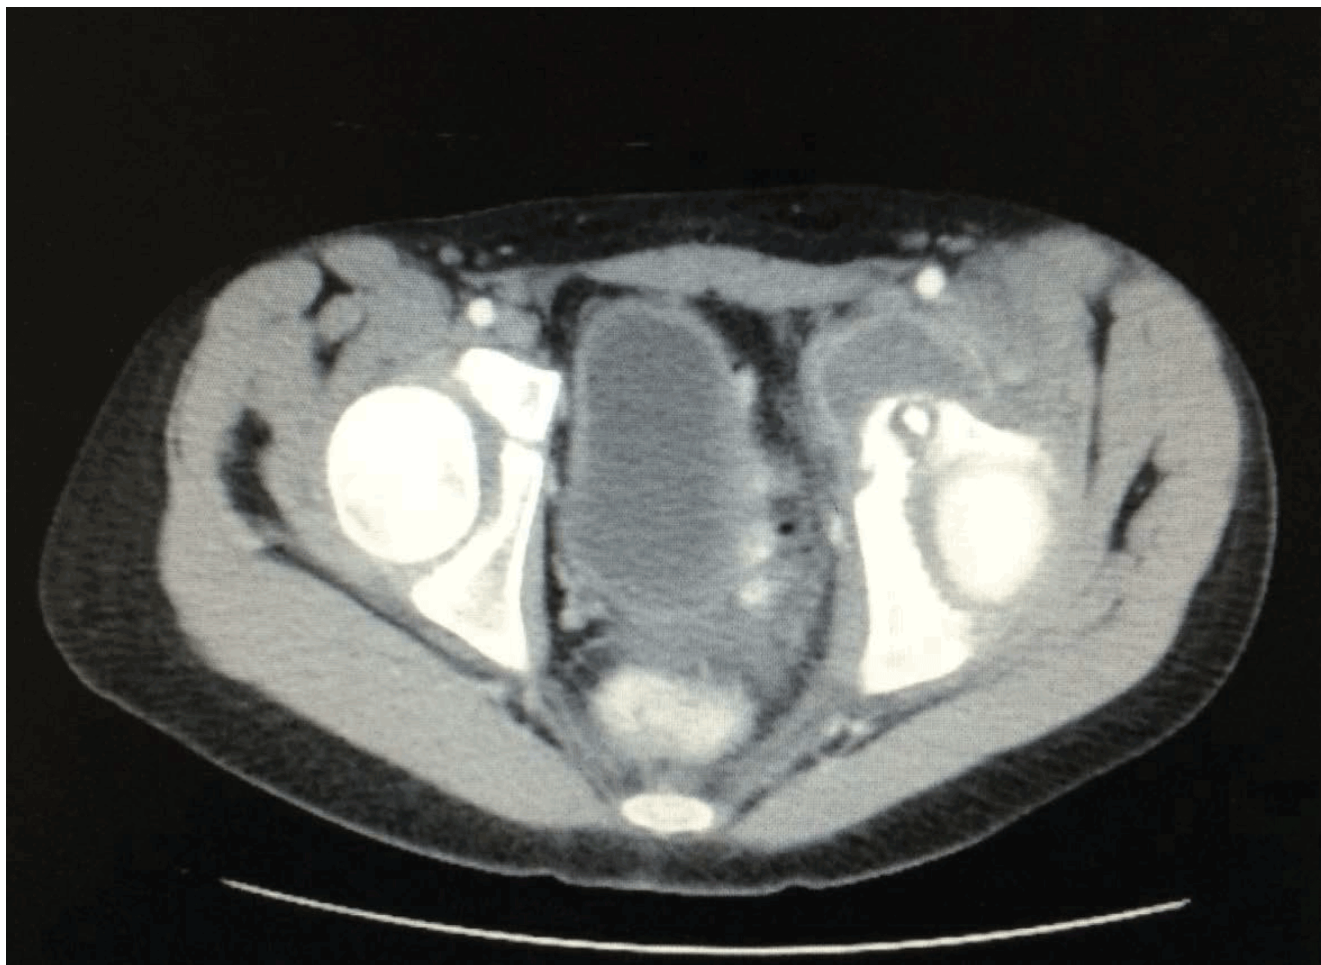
CT of the pelvis showing osteomyelitis of the left acetabulum with foci of bony sequestrum and a large periosteal/soft tissue abscess ventral to the left hip anterior column extending to the left iliac musculature.
